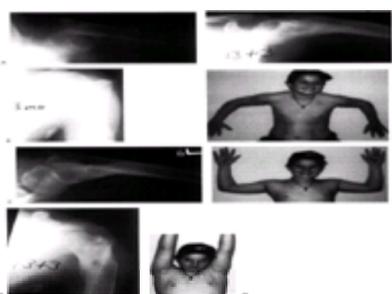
Proximal humeral fracture separation in a 12-year, 3-month-old boy. A: The initial fracture displacement was treated with sling and swathe. B and C: Three months after injury, healing and early remodeling are evident. D and E: Twelve months after injury, anteroposterior and lateral radiographs demonstrate continued remodeling. F and G: The patient recovered full range of motion with a 2-cm length discrepancy.
